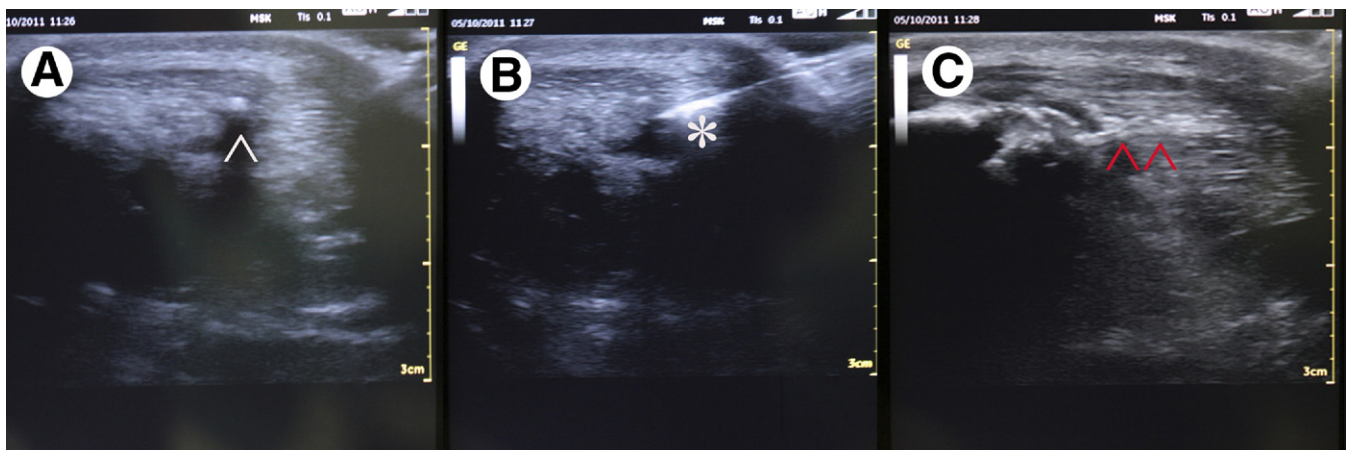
Ultrasound views of patellar tendon during PRP injection. (A) Calcification in the proximal pole (white arrowhead); (B) needle tip immediately adjacent to calcification; (C) image acquired immediately after infiltration shows clotted PRP.
